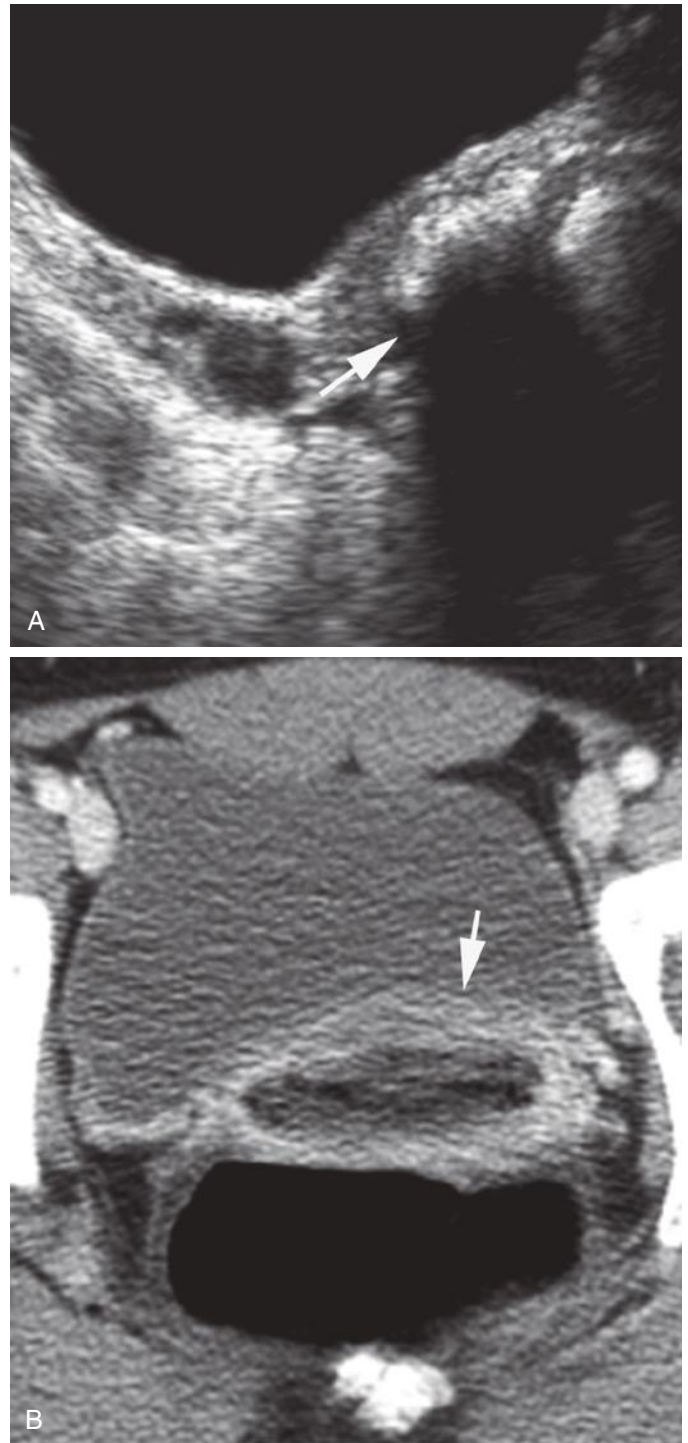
Vaginal foreign body in a 16-year-old girl with chronic abdominal pain. A, Sagittal ultrasound image of the pelvis shows echogenic material distending the vaginal lumen with pronounced distal acoustic shadowing (*arrow*). B, Axial, intravenous contrast-enhanced computed tomography image of the pelvis reveals thickened, hyperemic vaginal mucosa (*arrow*) with air and debris within the vaginal lumen. A retained tampon was discovered on speculum examination.
